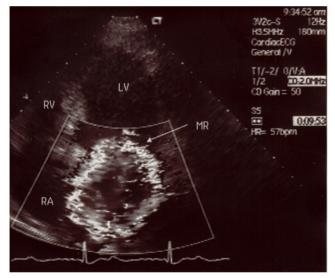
Transthoracic echo-severe mitral regurgitation.
